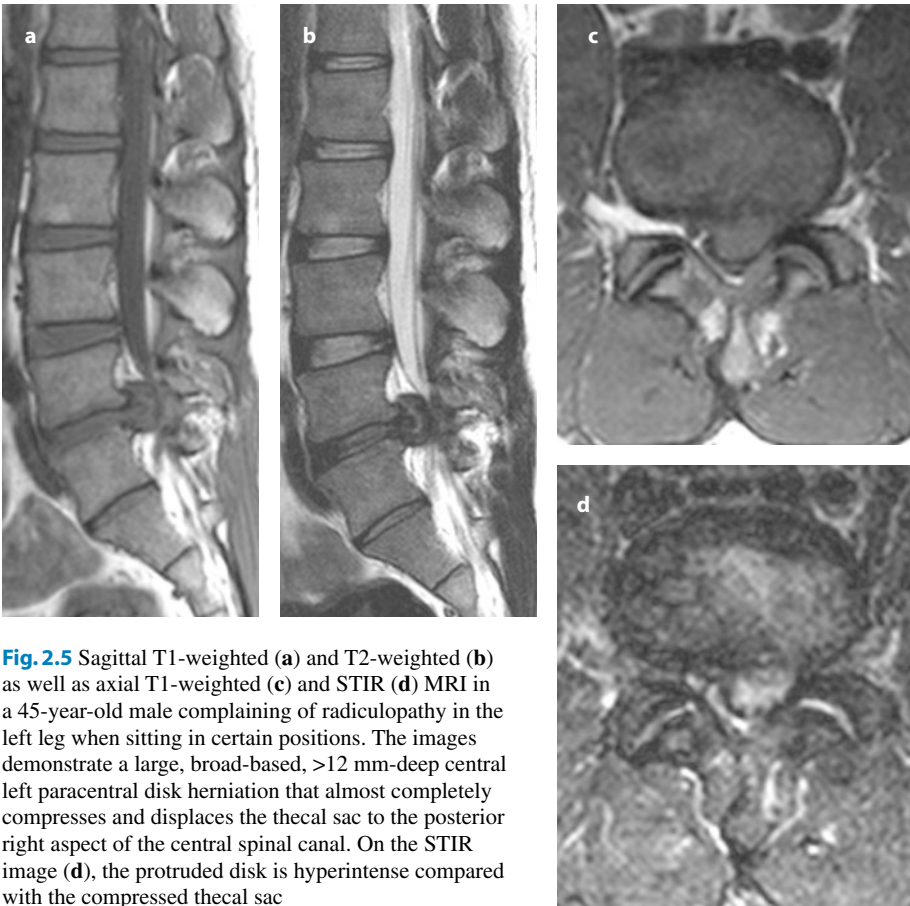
Sagittal T1-weighted (a) and T2-weighted (b) as well as axial T1-weighted (c) and STIR (d) MRI in a 45-year-old male complaining of radiculopathy in the left leg when sitting in certain positions. The images demonstrate a large, broad-based, >12 mm-deep central left paracentral disk herniation that almost completely compresses and displaces the thecal sac to the posterior right aspect of the central spinal canal. On the STIR image (d), the protruded disk is hyperintense compared with the compressed thecal sac
